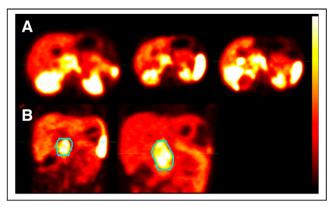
Early progression in primary mass detected on ⁶⁸Ga-DOTATATE PET/CT, with increase in volume not apparent on correlative MRI because of associated variable signal changes, edema, and necrosis. PET tumor thresholding allows accurate assessment of viable tumor volumes on axial PET images at, from left to right, initial staging, 2 mo, and 6 mo (A) and on coronal PET images at, from left to right, 2 and 6 mo (B).
